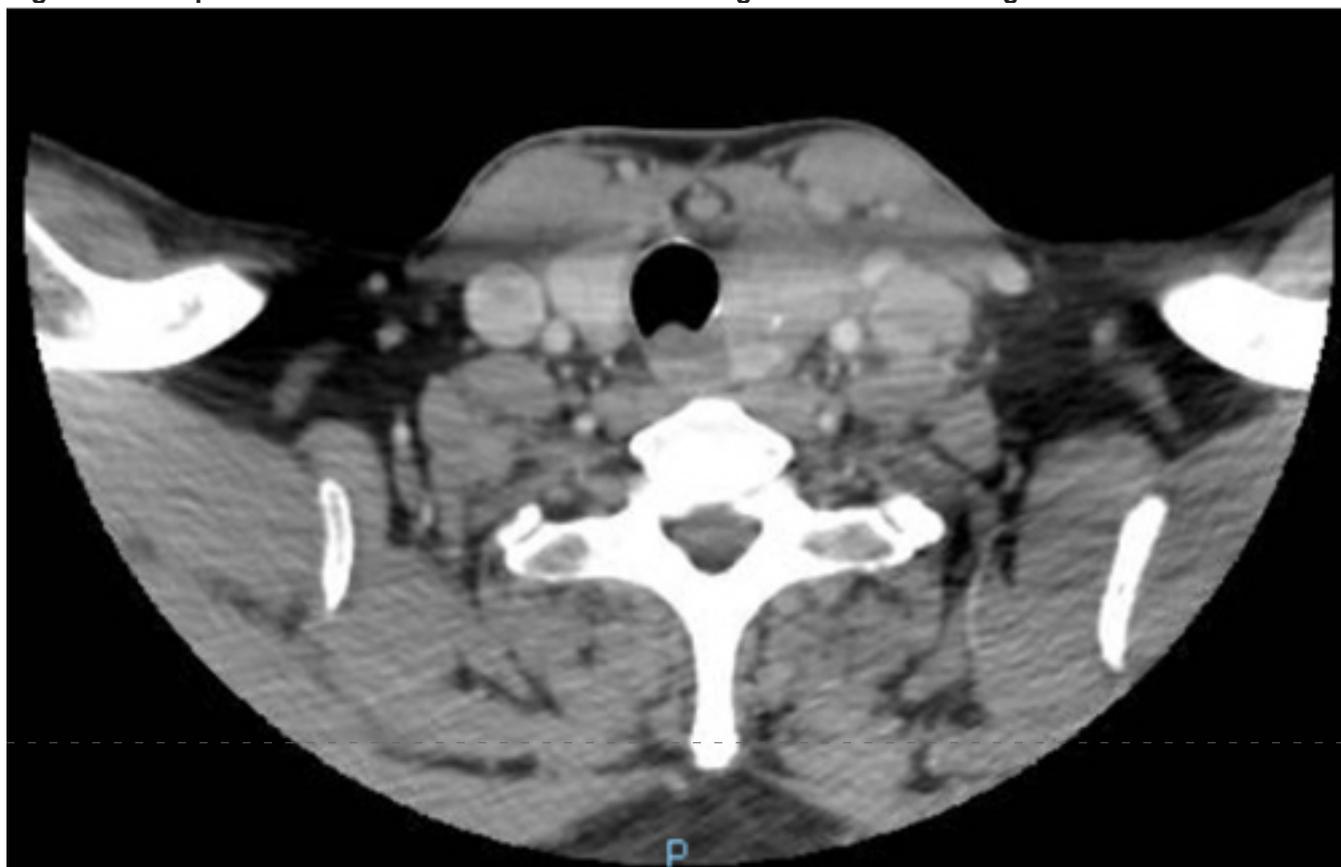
Post-operative CT scan of the neck demonstrating resolution of crescent trachea
